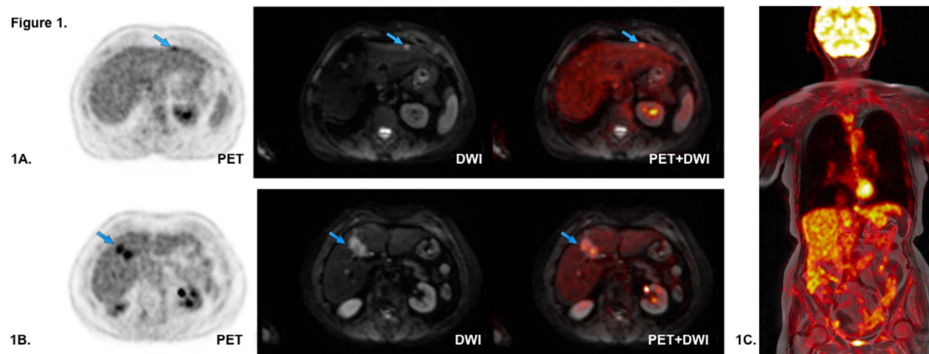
Examples of both PET and DWI images with PET+DWI fusion images. 1A. demonstrates a small lesion in the left hepatic lobe both restricts diffusion and is FDG avid. 1B. Large bilobed lesion within the right hepatic lobe and is intensely FDG and restricts diffusion. 1C. Fuse coronal image between a PET and coronal T1 images.
